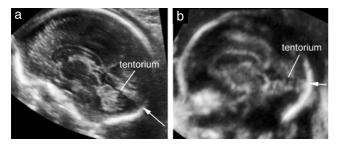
The position of the torcular *Herophili* (arrows) is inferred on ultrasound by the direction of the tentorium cerebelli. In (a) the torcular is found in a normal position, at about the same level as the site of insertion of the neck muscles on the posterior skull; this is a Blake's pouch cyst. In (b) the torcular is displaced higher than usual, indicating that this is a Dandy–Walker malformation.
